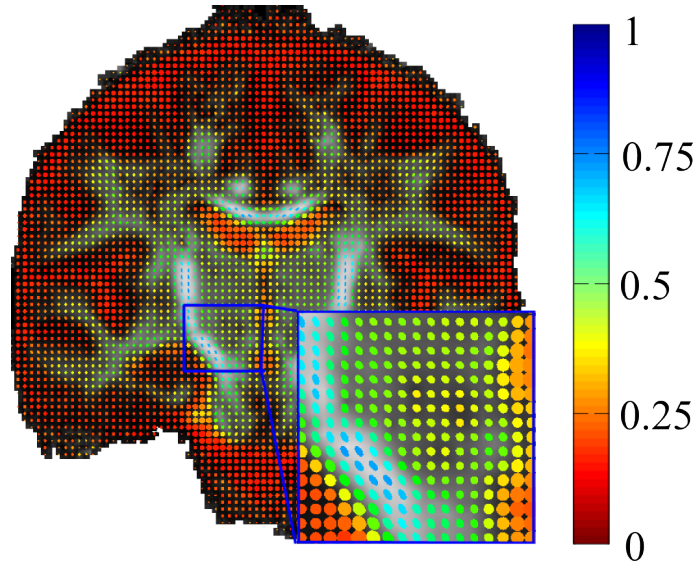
Diffusion tensor ellipsoids color-coded by their fractional anisotropy (FA) in a coronal section of a DTI MRI scan of the human brain from the SRI24 multi-channel brain atlas [104]. The ellipsoids are mainly non-uniform and of large FA in the white matter fibre tracts, whereas in ventricular CSF, the diffusivity is more uniform with small FA.
